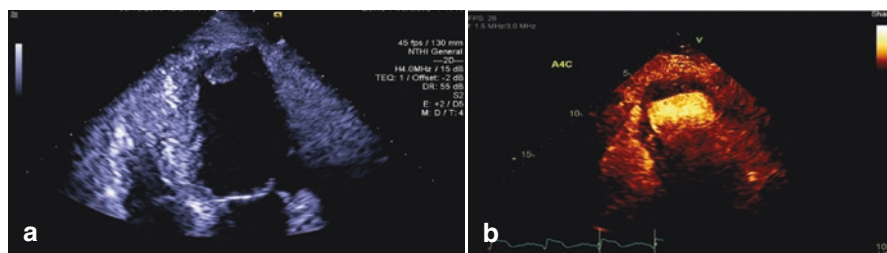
Apical four-chamber view of a transthoracic echocardiogram demonstrating a large left ventricular apical thrombus (a). Injection of an echo-contrast agent delineates the linear appearance of this large apical thrombus (b)
